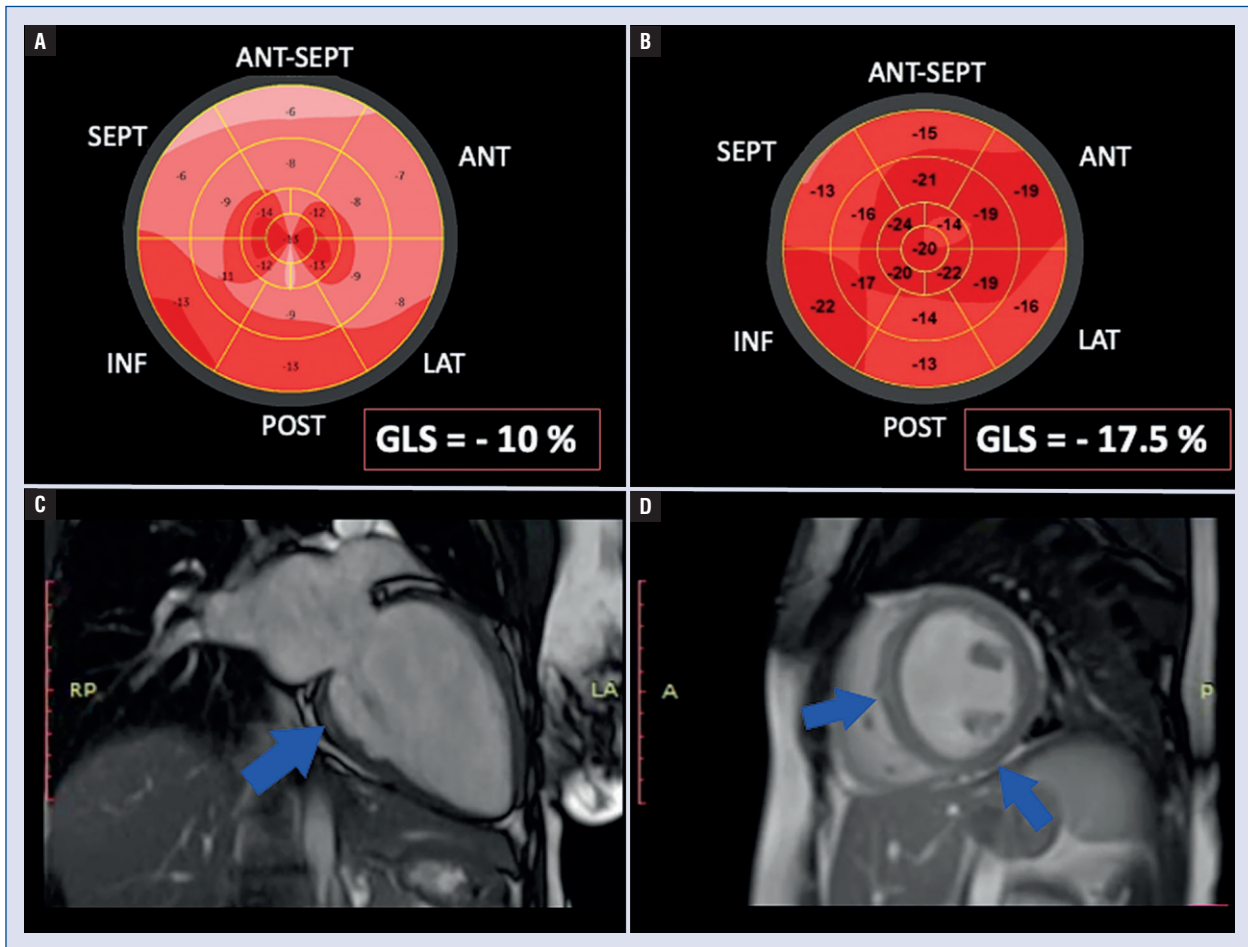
A. Left ventricular global longitudinal strain polar map, 4 days after vaccination; B. Left ventricular global longitudinal strain polar map after 6 months of follow-up; C. Late gadolinium enhancement (blue arrows) in magnetic resonance imaging — 2-chamber view, 44 days after vaccination; D. Late gadolinium enhancement (blue arrows) in magnetic resonance imaging — left ventricular short axis, 44 days after vaccination.
